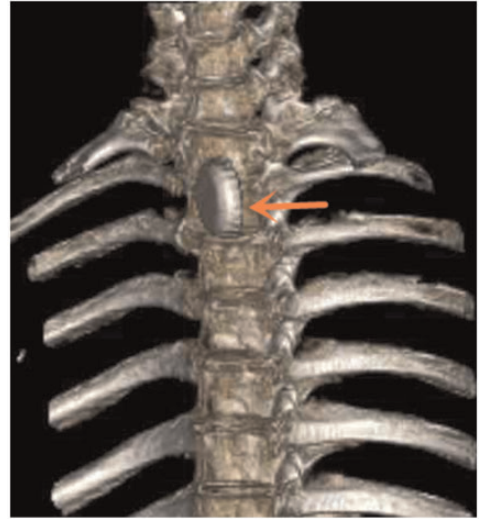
Chest radiograph (three-dimensional reconstruction) showing a metal bottle cap impacted at the T1–T2 cervical spine level (arrow).
